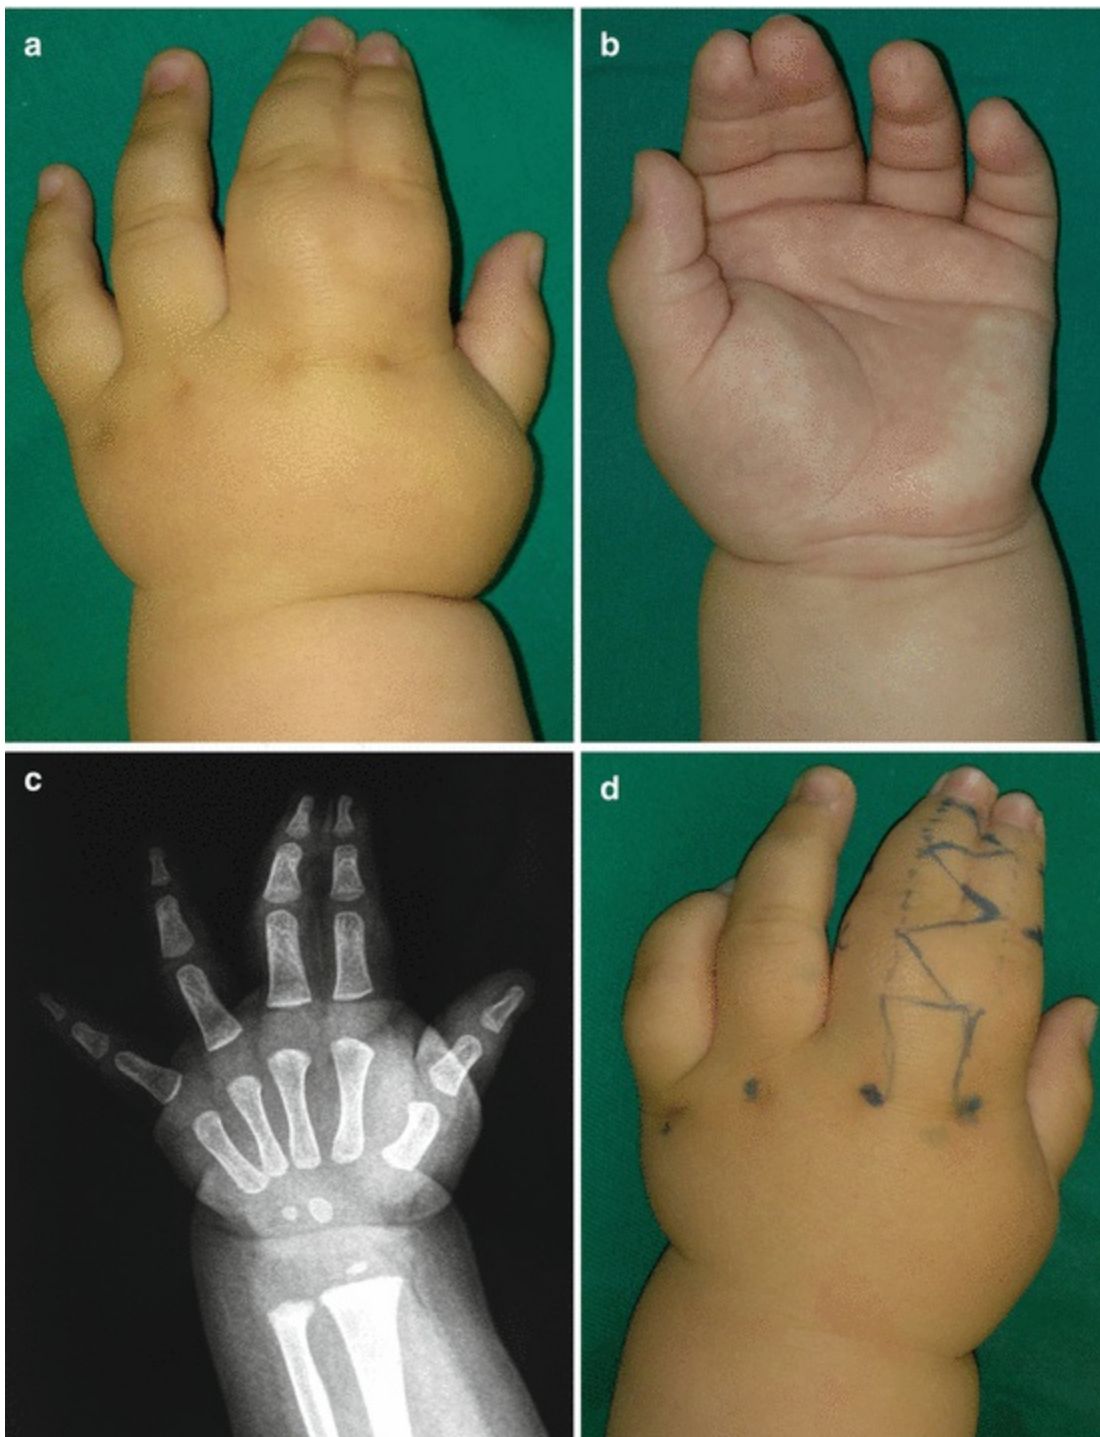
Surgical treatment of syndactyly: (a) preoperative dorsal view; (b) preoperative palmar view; (c) preoperative radiography; (d–f) incision markings and incisions; (g, h) result
